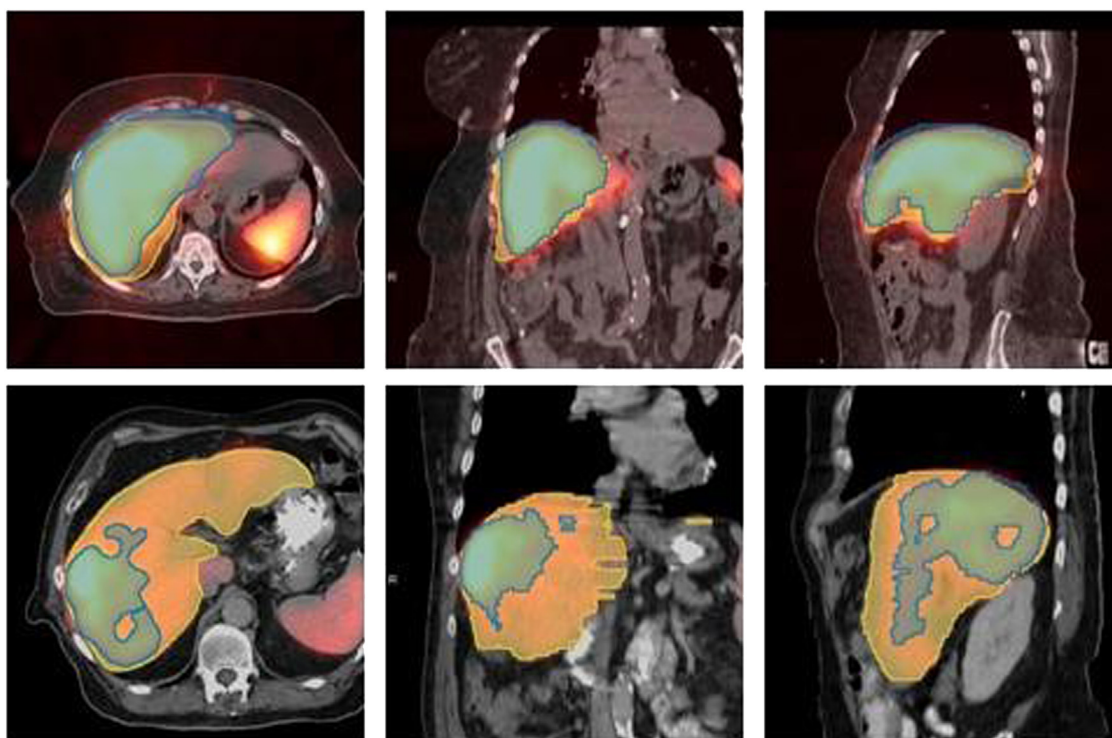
From left to right: Axial, coronal, and sagittal fused single-photon emission computed tomography/computed tomography liver images for noncirrhotic (top) and Child-Pugh B cirrhotic (bottom) patients. Anatomical liver contours defined on planning computed tomography are shown in yellow, and the single-photon emission computed tomography defined functional liver is shown in blue.
